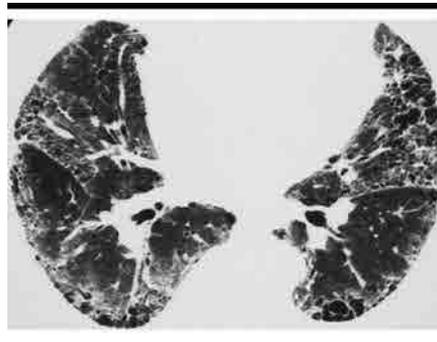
UIP pattern in a 59-year-old man with asbestosis. (a) Transverse thin-section CT image shows predominantly peripheral honeycombing associated with reticular pattern and a lesser proportion of ground-glass opacification. (b) Transverse CT image (mediastinal window) shows bilateral noncalcified pleural plaques (arrows).
